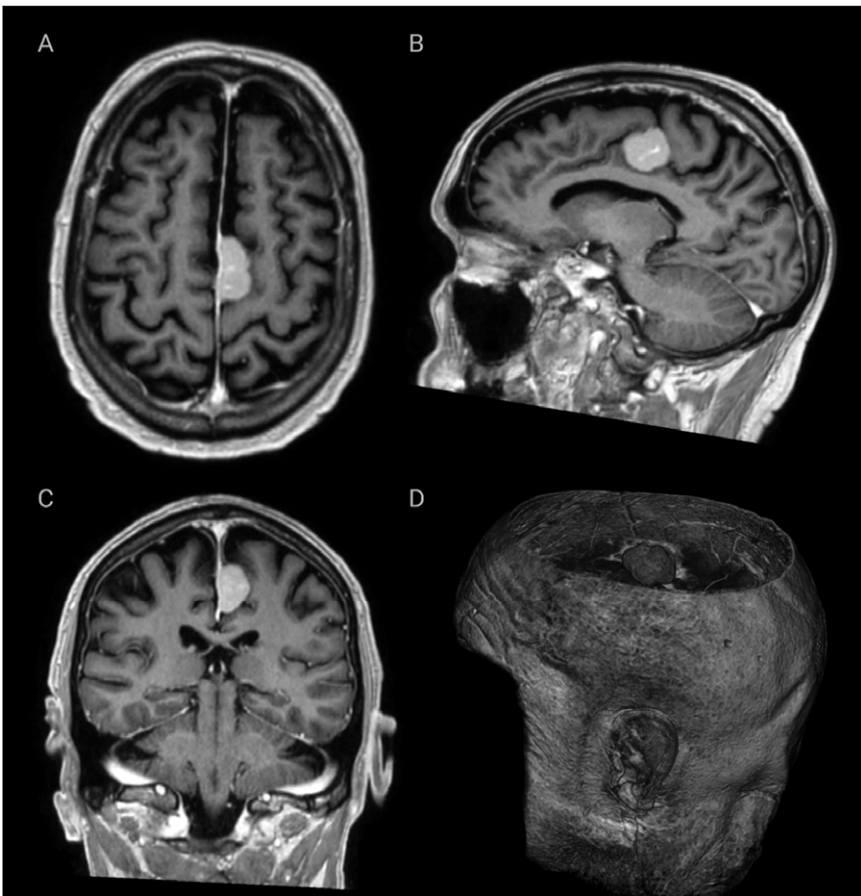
MRI with gadolinium-enhanced T1 images of an incidentally discovered asymptomatic falx meningioma: A) transverse image, B) sagittal image, C) coronal image, D) 3D reconstruction. Note the dural tail sign on transverse and coronal images.
